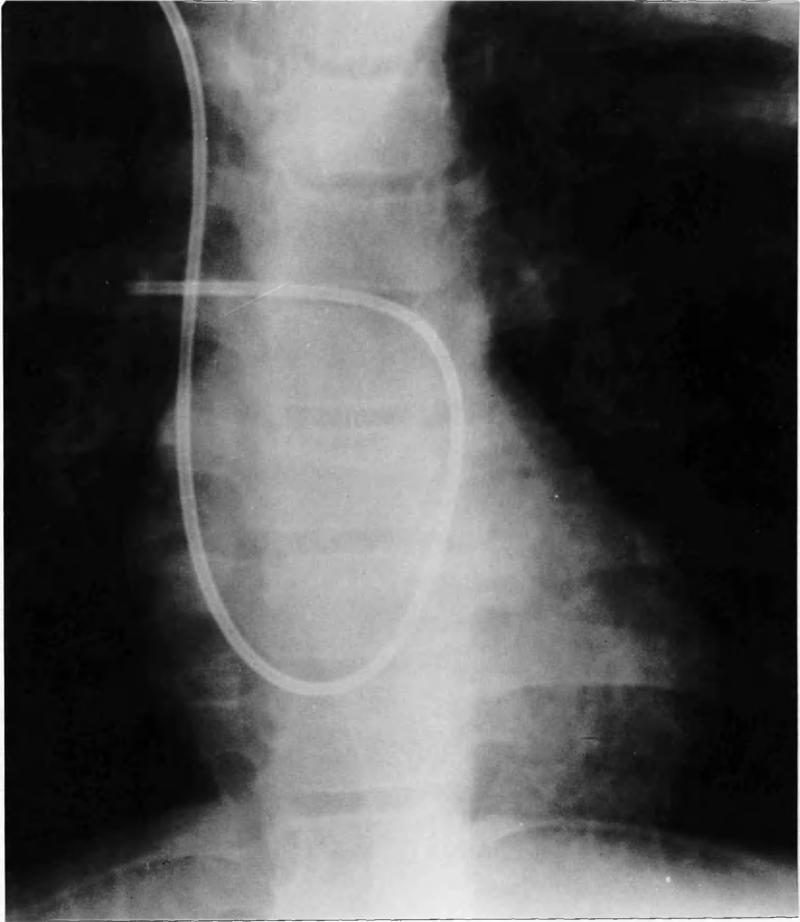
(a). X-ray appearance of the cardiac catheter with the tip advanced to the right main pulmonary artery. The catheter has followed a normal course through the right atrium and ventricle and has been manipulated through the pulmonary valve to the right main pulmonary artery.
